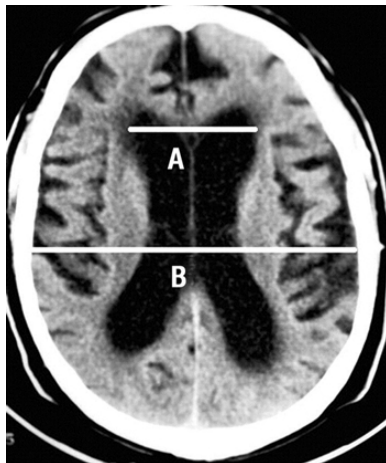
Lines indicating diameters used for calculation of Evan's ratio from CT brain scan:
